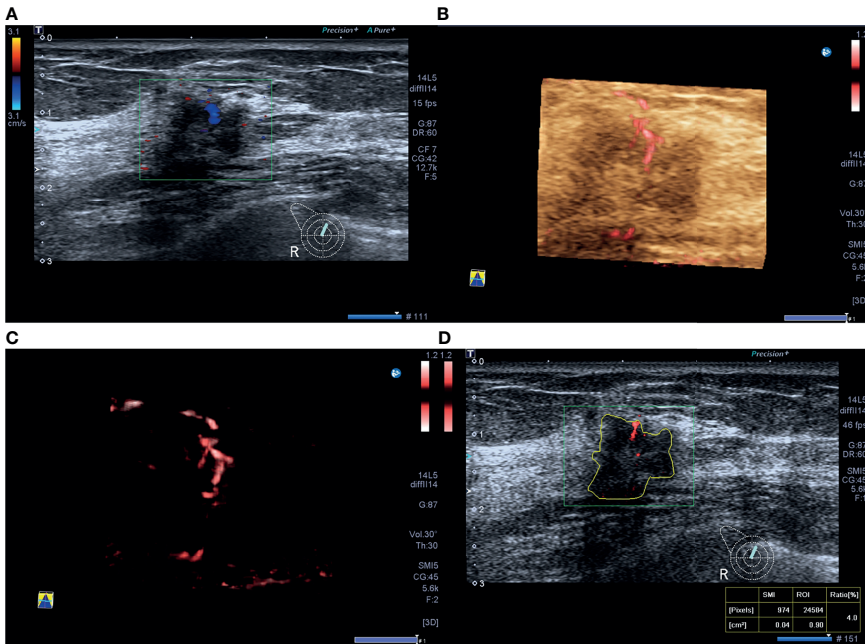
A 46-year-old woman with luminal A invasive ductal cancer [1.7 cm, ER 90%, PR 95%, HER-2(-), Ki-67 10%, nuclear grade 1, T1N0M0]. (A) Color Doppler flow imaging image shows linear blood flow signals. (B, C) Smart three-dimensional superb microvascular imaging reveals linear blood flow. (D) Vascular index was measured on the plane containing the most abundant vasculature with a value of 4.0%.
